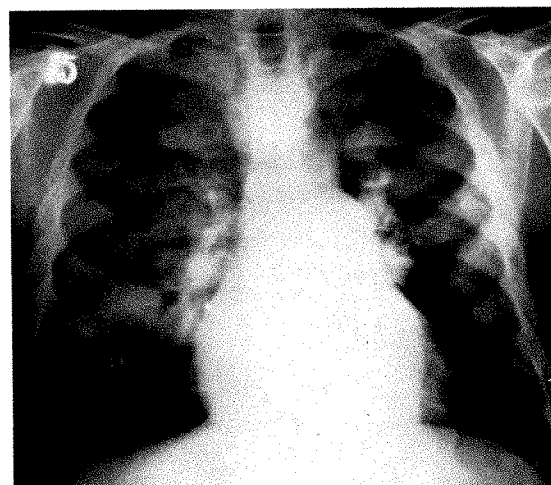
Case V. Posteroanterior roentgenogram of the chest showing multiple bilateral masses.
